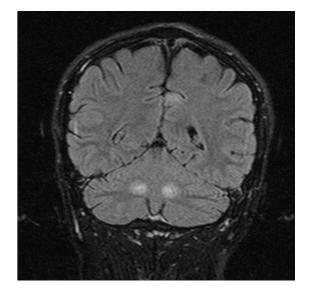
Cranial MRI performed after development of the cerebellar findings: FLAIR sequences showed hyperintensities in bilateral cerebellar dentate nuclei.
